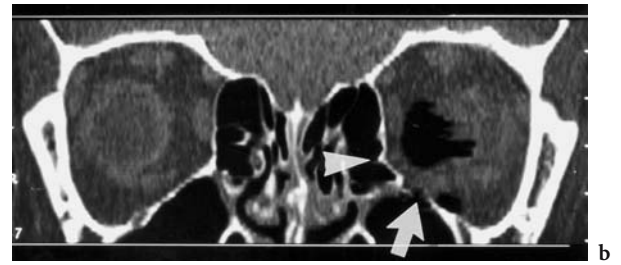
A 14-year-old boy after blunt orbital trauma. Diagnosis: blow-out fracture. HR-CT: a Axial view: despite the slightly swollen conjunctiva, a retrobulbar, intraconal emphysema is seen medial of the optic nerve (*white arrowheads*). b Coronal reconstruction demonstrating a small fracture of the medial orbital floor (*white arrow*) and a fracture of the lamina papyracea (*white arrowhead*), the cause of the orbital emphysema. (With permission of MÜLLER-FORELL 1998)
